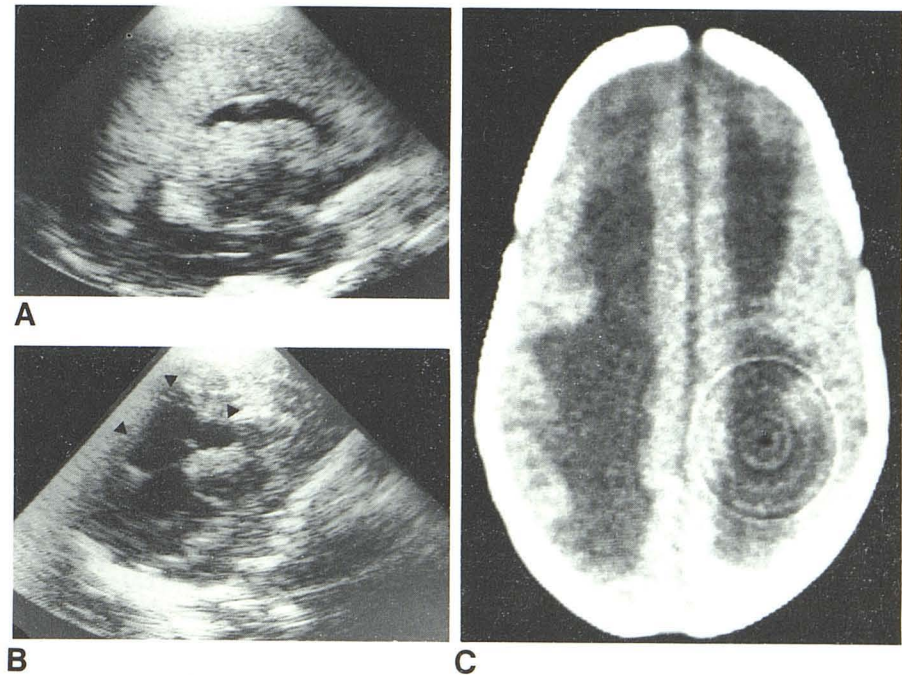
Contour irregularity of lateral ventricles caused by periventricular cysts in neonate. A, Angled sagittal sonogram. Echogenic zone surrounding posterior part of lateral ventricles. C, 2 weeks later. Large cysts have developed in same area. C, 4 weeks later. CT shows irregular contour of ventricles, caused by juxtaposed periventricular cysts.
